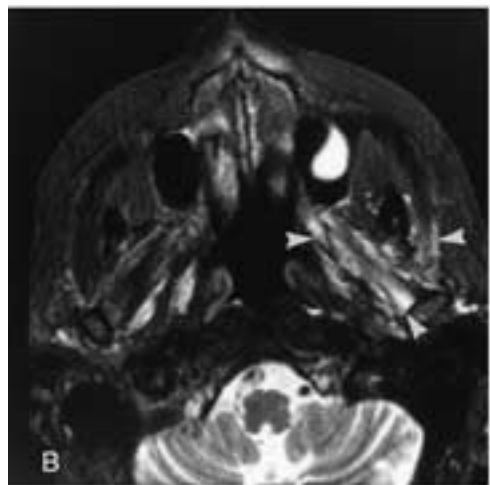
Squamous cell carcinoma of the left lower lip with extensive PNS. The patient had had a lesion resected from his lip 11 months earlier. At the time of recent presentation, the patient not only had neuropathy of the entire trigeminal distribution, but a facial nerve paralysis as well. No local recurrence was clinically apparent. A, Axial contrast-enhanced, fat-suppressed MR image at the time of recent presentation shows tumor in Meckel's cave (*black arrow*) and extension of tumor posteriorly along the main trunk of the left trigeminal nerve (*arrowheads*). These findings explain the patient's complete trigeminal neuropathy. However, the facial palsy could not be explained. Although perineural involvement of the greater superficial petrosal nerve and geniculate ganglion was suspected, the imaging was equivocal. Axial T2-weighted (B) and contrast-enhanced, fat-suppressed T1-weighted (C) MR images show hyperintense signal and abnormal enhancement, respectively, in the left masticator muscles (*arrowheads*). These muscles were not atrophic; this represents subacute denervation secondary to tumor involvement of the proximal mandibular nerve, not tumor within the masticator space. The patient had no trismus, only weakness in opening the mouth. D and E, Axial contrast-enhanced, fat-suppressed T1-weighted images obtained 3 months after images A to C. D, Progression of the main trigeminal trunk disease, now directly invading the pons (*arrowhead*), is seen. In E, there is tumor involvement of the geniculate ganglion (*black arrow*), proximal tympanic (*arrowhead*), and labyrinthine segments (*white arrow*) of the left facial nerve. This was not visible 3 months previously and helped explain the patient's facial palsy. This facial nerve disease was presumably a skip lesion along the left greater superficial petrosal nerve. In both D and E, there is probably antegrade PNS to involve the PPF (*black dots*). (From Ginsberg LE. Imaging of perineural tumor spread in head and neck cancer. *Semin Ultrasound CT MR* 1999;2:175–186.)
